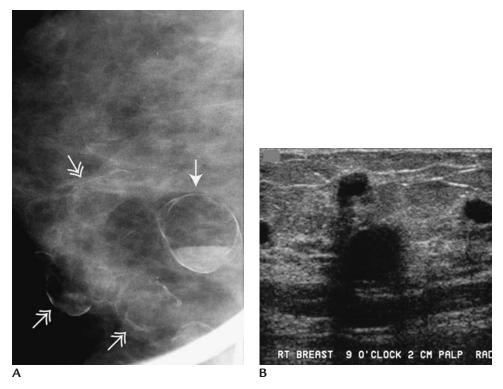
Oil cysts. (A) Cluster of fat containing masses (*double headed arrows*) with rimlike calcifications. One of these (*arrow*) has a fat-fluid level. (B) Anechoic masses some with posterior acoustic shadowing are imaged on ultrasound. Given the presence of fat containing masses mammographically, ultrasound is not indicated (included here out of interest).
